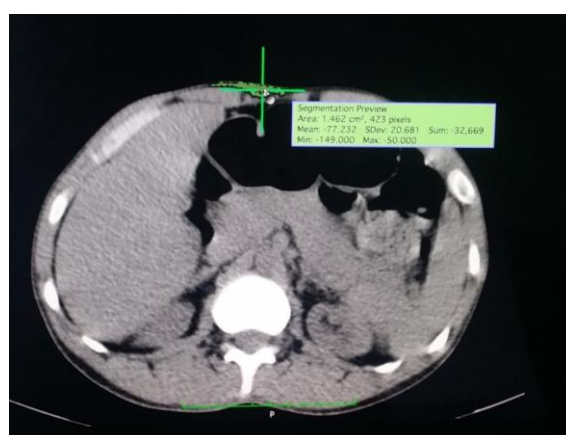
The CT scan of the patient showed the lowest amount of subcutaneous fat.
